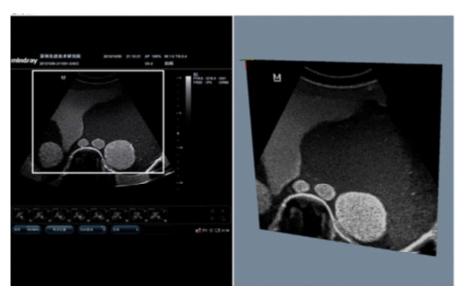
The selection of ROI in our custom-designed software system. On the left view pane, it demonstrates a rectangle selected ROI in B-scan video frame captured from ultrasound scanner. On the right view pane, it is the cropped ROI with its position and orientation adjusted in real-time according to the labeled spatial data during data acquisition (*Tiexiang et al., 2013*).
